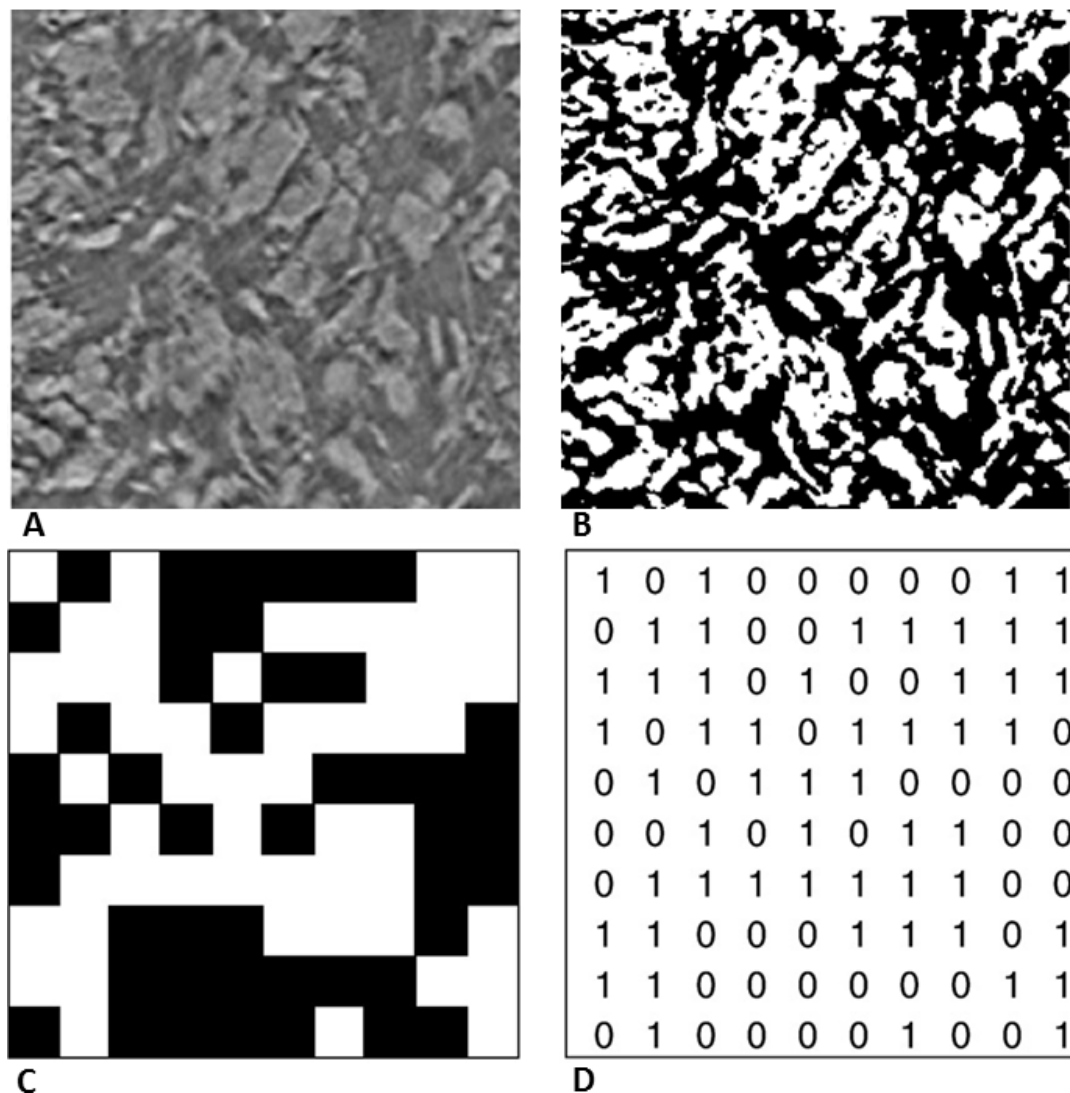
Binarization of a Chondro-Gide® scaffold 2D CT slice (A-B) ; a synthetic random black (solid) and white (pore) map (C) and a binary representation of the same map (D).
